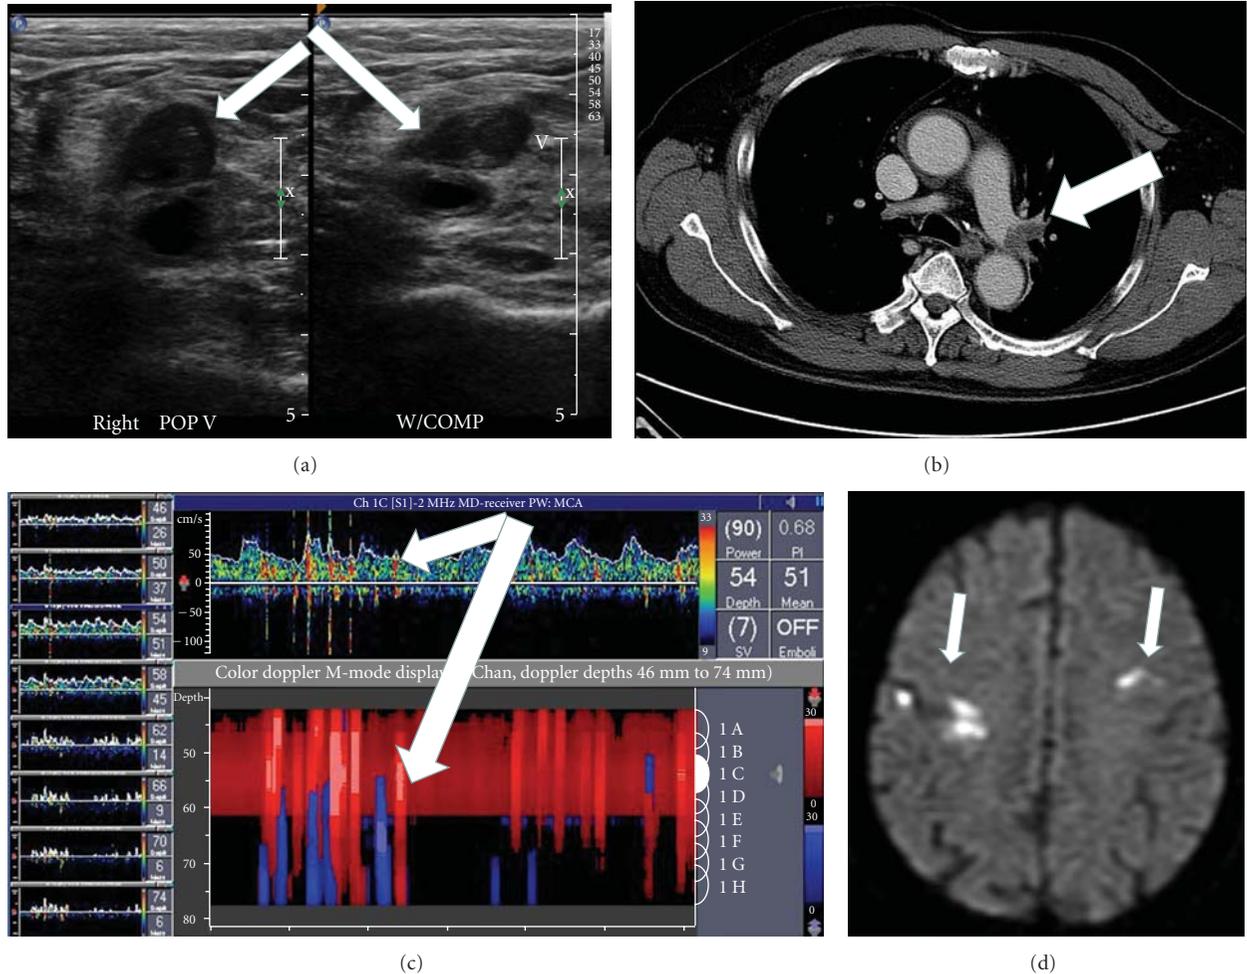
A 27-year-old woman, without any vascular risk factors, presented with mild right-sided weakness of suddenonset. She was noted to have swelling and pain in the right leg. Duplex sonography revealed extensive deep vein thrombosis involving the popliteal as well as superficial femoral vein, as characteristic noncompressibility and echogenic mass in the venous lumen. (a) Computerized tomographic angiography of thorax revealed filling defect in the left pulmonary artery. (b) Transcranial Doppler ultrasonographic monitoring of left middle cerebral artery during the “bubble test” (injection of agitated 9 mL normal saline and 1 mL air) revealed numerous microembolic signals, (c) suggestive of a right-to-left shunt (patent foramen ovale). Multiple acute ischemic infarcts involving many arterial territories were evident on the diffusion-weighted magnetic resonance imaging of the brain. (d) Blood tests were positive for lupus anticoagulant and anticardiolipin antibodies.
